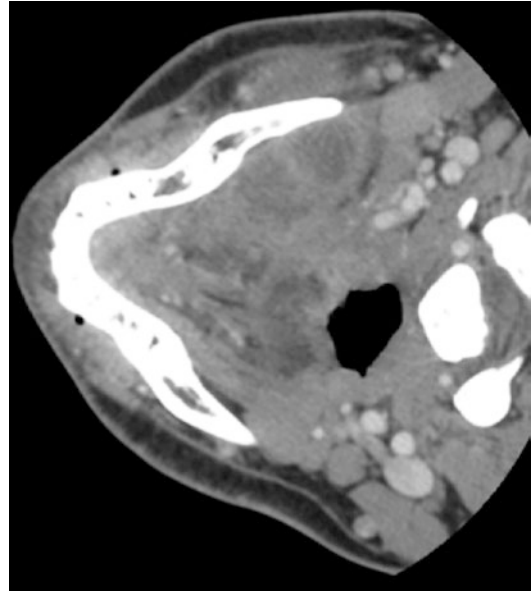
CT scan with contrast at the level of the mandible. (Image courtesy of Dr. Damian Findlay)
